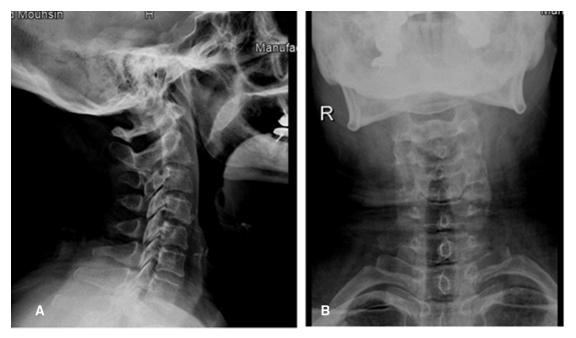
Eight months after treatment, lateral (A) and anteroposterior (B) cervical spine x-ray images showed normal findings.
